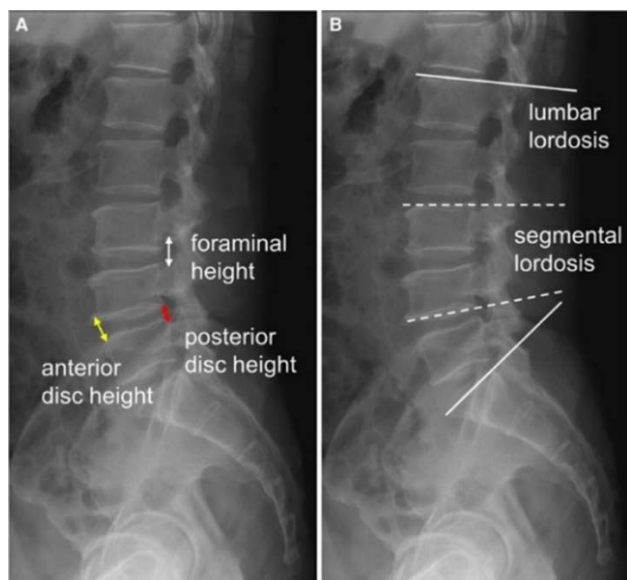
Lumbo-sacral parameters on lateral x-ray.
